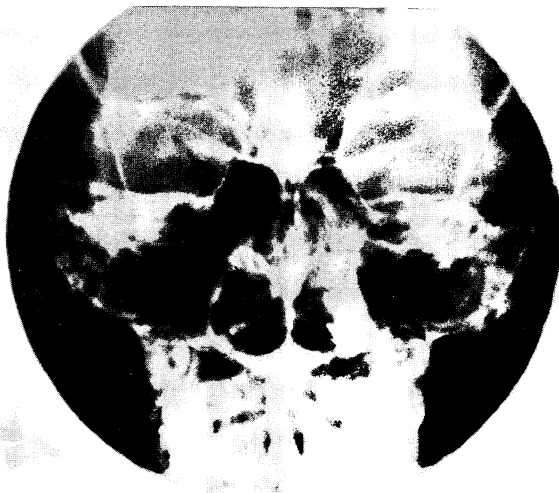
Radiograph of paranasal sinuses showing a radiopaque mass in the left maxillary sinus
